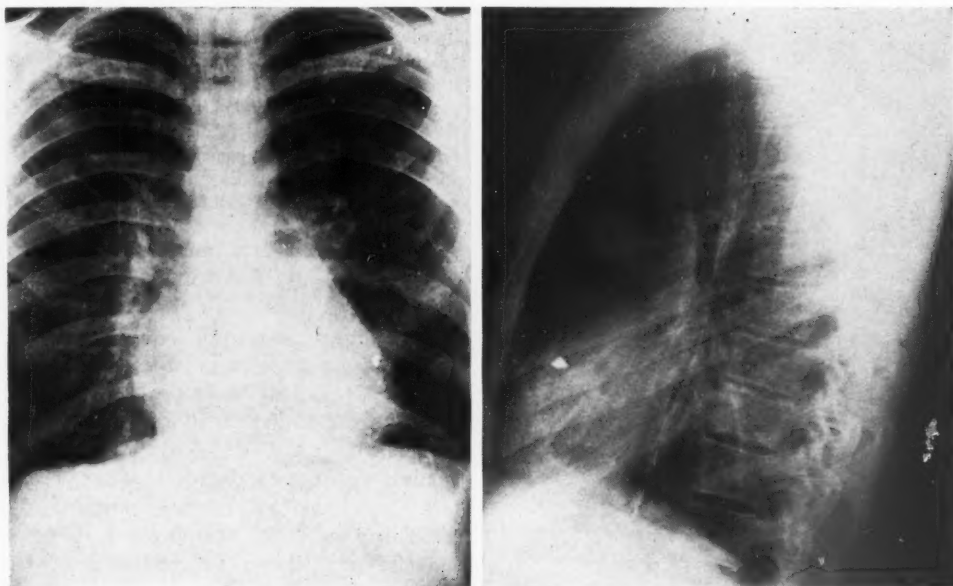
Postero-anterior and lateral chest roentgenograms after thoracotomy, demonstrating a retained shell fragment in the anterolateral aspect of the left ventricle. This fragment was believed to be accessible, but could not be found at operation.
